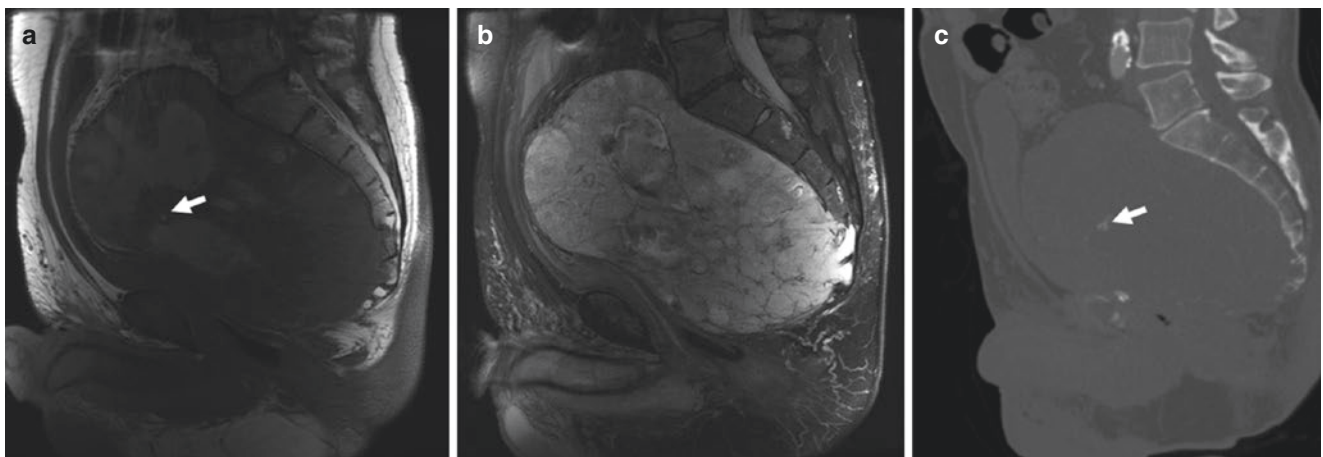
Sagittal T1 (a) MR image demonstrating slightly hypointense mass with areas of increased signal intensity consistent with hemorrhage arising from the coccyx and S5 vertebrae. Sagittal T2-weighted
